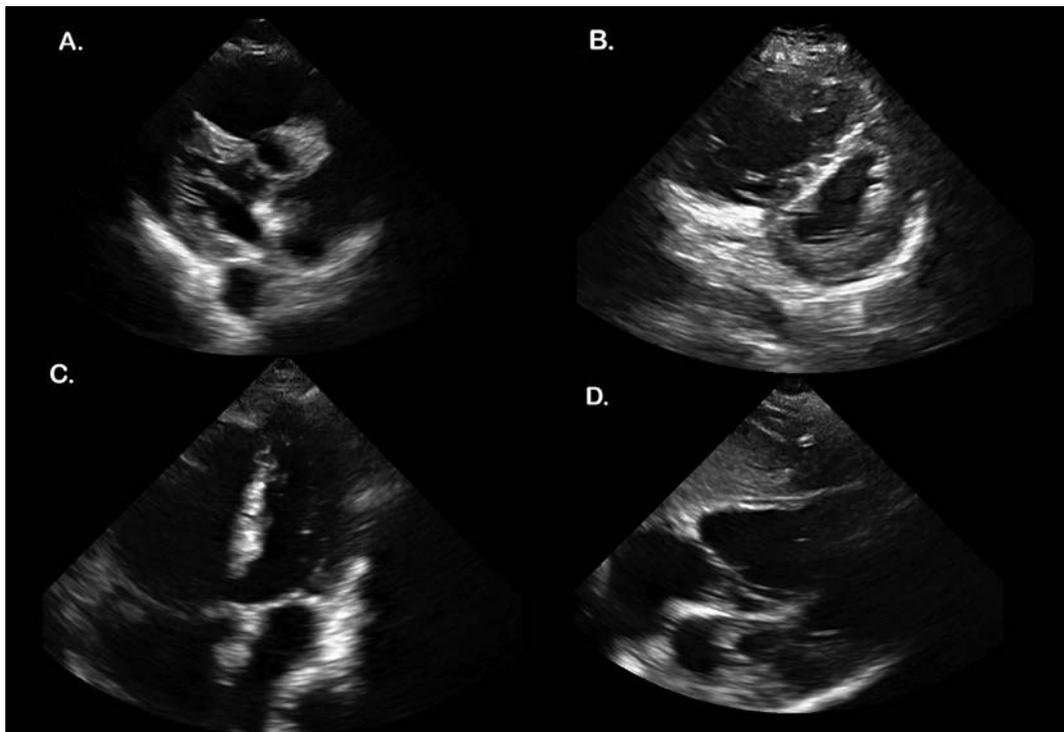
Pericardial effusion and cardiac tamponade. A. Parasternal long-axis; B. Parasternal short-axis; C. Apical 4-chamber; D. Subxiphoid long-axis. Images courtesy of Stephen Alerhand, MD (A, C, D) and Lauren Ann J. Selame, MD (B).
